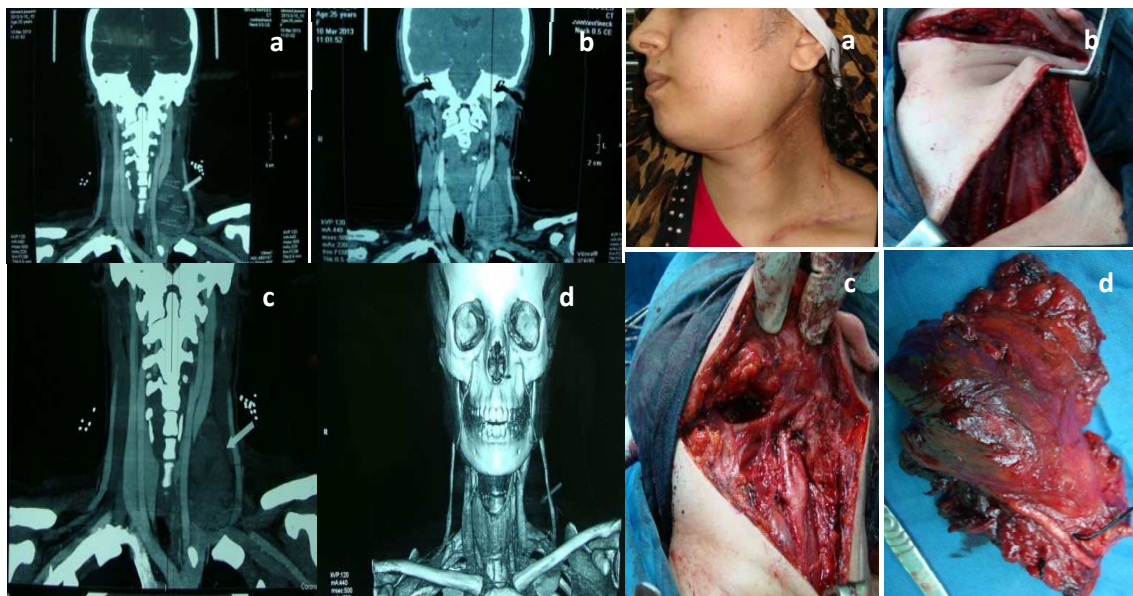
CT scan axial section, include enlargement of neck, showing the cervical regional metastasis. Figure (1B, a-d): Stages of operation in a patient with OSCC.
